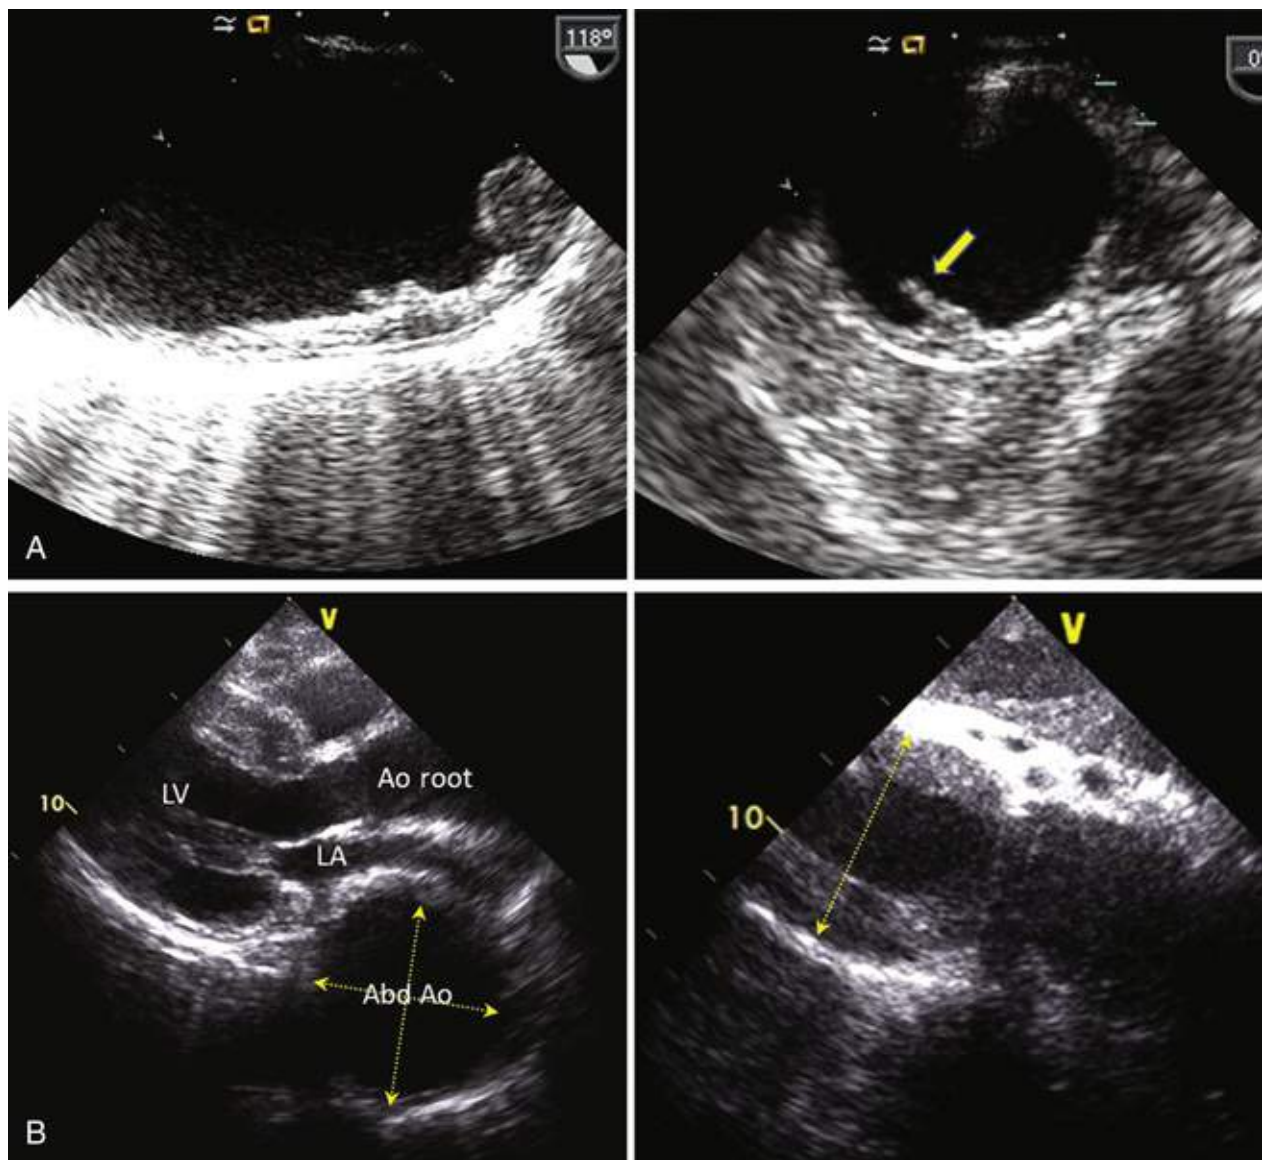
Aortic atheroma and aneurysm. A, TEE views of complex aortic atheroma in the ascending aorta. In the long-axis view (left), the atheroma is seen to be irregular and measures up to 1.0 cm in thickness. In the short-axis view (right), a protuberant finger-like atheroma is seen and is independently mobile. B, Transthoracic parasternal long-axis (left) and subcostal (right) views of a large 7-cm-diameter descending thoracoabdominal aortic aneurysm (*dotted arrows* spanning the diameter) compressing the posterior aspect of the left atrium (*LA*), within which diffuse circumferential thick mural thrombus is layered. *Ao*, Aortic; *LV*, left ventricle.
